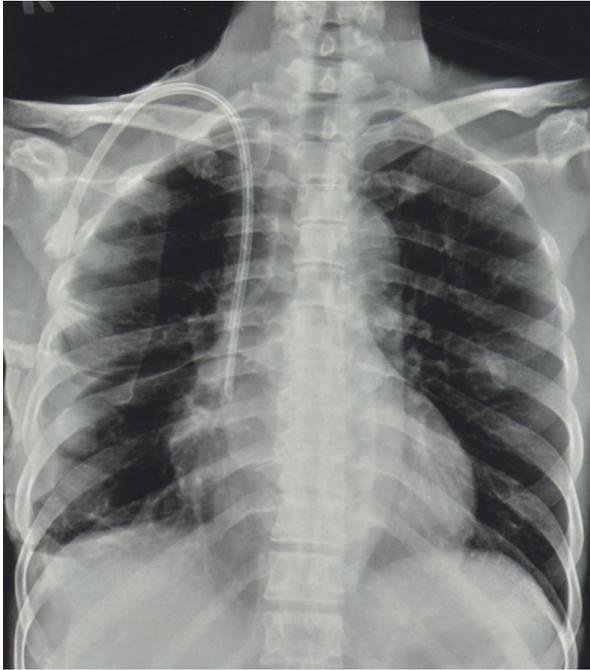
After video-assisted thoracoscopy with endoscopic sutures for the diaphragmatic defects, the patient chose hemodialysis as a renal replacement. Chest X-ray follow-up showed the Hickman catheter in situ without recurrence of hydrothorax.
